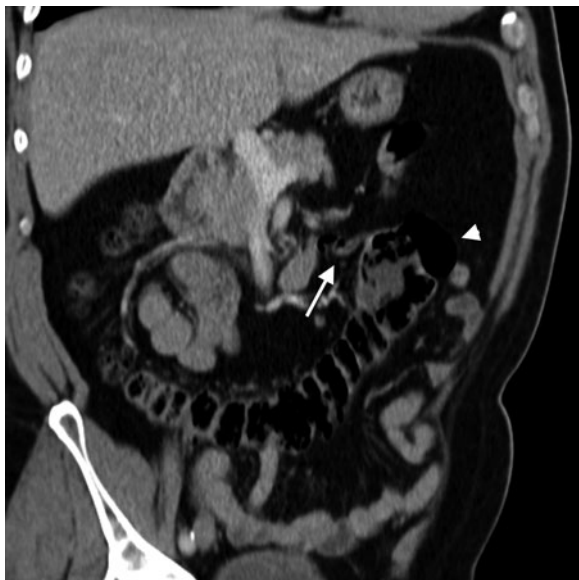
Normal appendix (*arrow*) and cecum (*arrowhead*) located in the left upper abdominal quadrant on a coronal CT reformation
